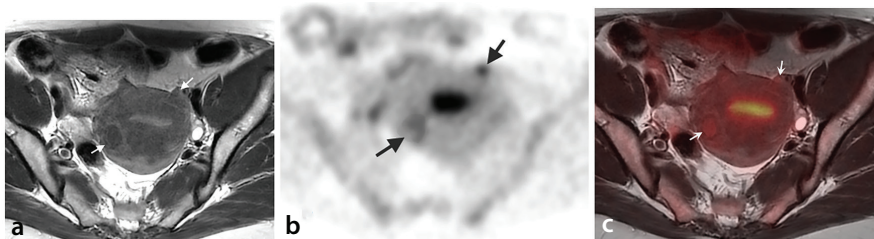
Uterine leiomyomas. The axial T2-weighted magnetic resonance image (MRI) (a) shows two leiomyomas with typical low signal intensity (arrows). The axial positron emission tomography (PET) (b) and axial fused PET/MRI (c) show mild FDG uptake in the leiomyomas, better distinguishable in the PET image [black arrows in (b)]. FDG uptake in leiomyomas may vary during the menstrual cycle and may be higher in the proliferative phase. The high activity in the uterine cavity in this patient is physiological and is related to menstruation. FDG, fluorodeoxyglucose.
